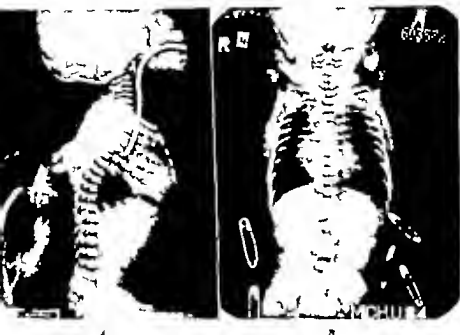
(Case D. H.)—A X-ray taken the day prior to admission shows the ribcage and the blind upper esophageal pouch. B The posteroanterior film taken on the day of admission reveals the prominence of the right cardiac silhouette and the retained masses of air in the stomach.
